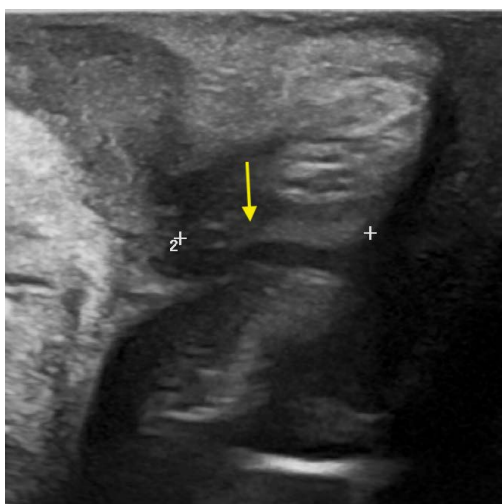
Transperineal ultrasound scan performed with a linear probe showed a small subcutaneous abscess collection, located dorsally and deeply to the right labia majora and a fistulous tract between rectum and vagina (arrow).
